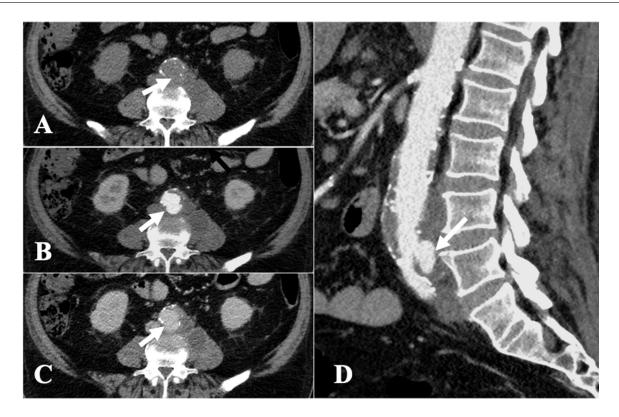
Abdomino-pelvic CT reveals a pseudoaneurysm of the distal abdominal aorta measuring 45 mm of maximal axial diameter. On non-enhanced CT images (A) a "fracture" of the calcium ring can be appreciated on the posterior aspect of the aorta (white arrow), a sign considered to be indicative of impeding aneurysmal rupture. On the arterial phase (B) a posterior outpouching of the distal aorta (white arrows) is seen, corresponding to the pseudoaneurysm. Its extension can be better appreciated on the sagittal plane image (D). On both the arterial (B; D) and venous phases (C) densification of the peri-aortic tissues is seen with loss of the fat planes between the aorta and the left psoas muscle. Signs of rupture, such as active contrast extravasation or retroperitoneal hematoma, were absent.
